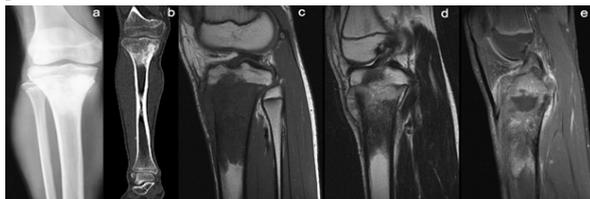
Osteogenic Sarcoma proximal tibia a) X ray knee AP and lateral showing osteosclerotic lesion. b) CT scan shows hyperdense lesion in tibia. c) MRI T1W sagittal shows marrow involvement reaching articular surface with cortical break anteriorly. d) and e) T2W and Post Gad T1 shows lifting of periosteum anteriorly with involvement of anterior cruciate ligament suggestive of joint involvement.
